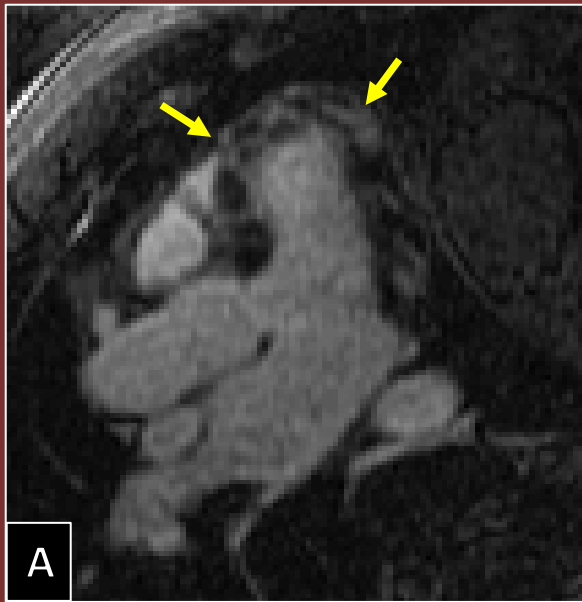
Figure (A): Late gadolinium enhancement (LGE) cardiac MRI LVOT view.
